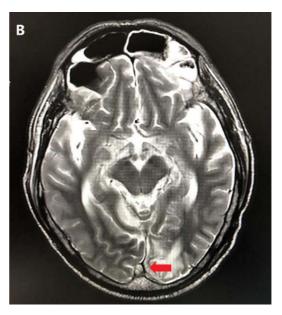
MRI brain with contrast: cystic lesion (1.2 × 1.5 cm) with ring enhancement located in left occipital lobe (A), diffuse meningeal enhancement and superior sagittal sinus thrombus (B).
